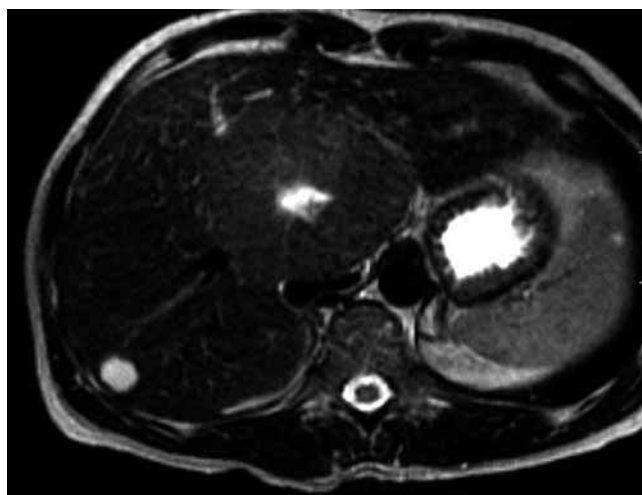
FNH of the caudate lobe, with typical signs on T2-weighted images, associated with a small hemangioma of the right lobe.
